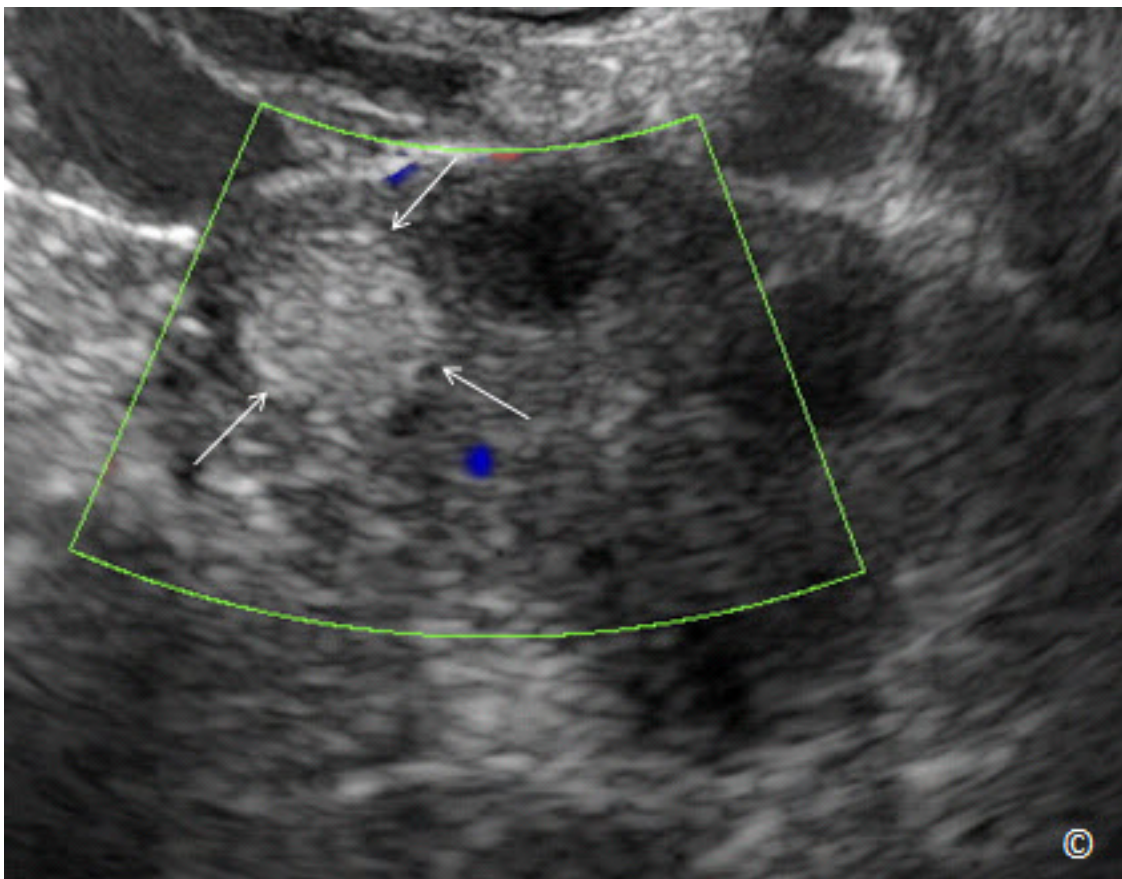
Transvaginal ultrasound with color Doppler of a small dermoid (arrows), located within the ovary.
